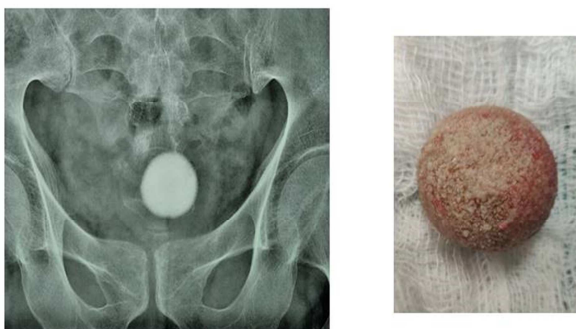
(a-b) a. X-ray Pelvis showing Bladder stone b. Bladder stone after cystolithotomy
